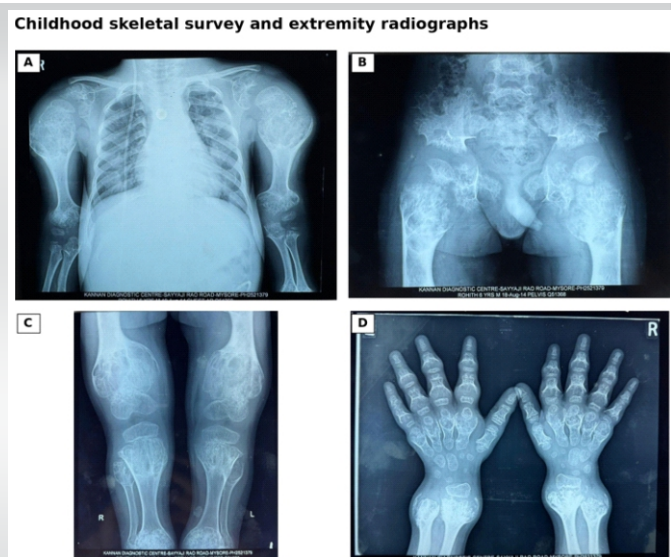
Childhood skeletal survey and extremity radiographs. (a) Bilateral upper-limb and shoulder radiograph showing expansile chondroid lesions, (b) Pelvic radiograph showing bilateral pelvic and proximal femoral involvement, (c) Bilateral knee radiograph showing metaphyseal expansion and deformity, (d) Hand radiograph showing multiple expansile lesions involving the metacarpals, phalanges, and distal forearms.
